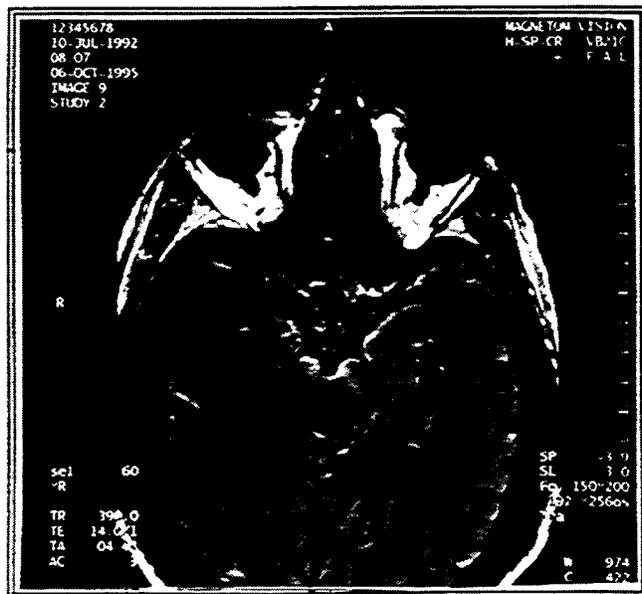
T1 Weighted MRI of a Head
